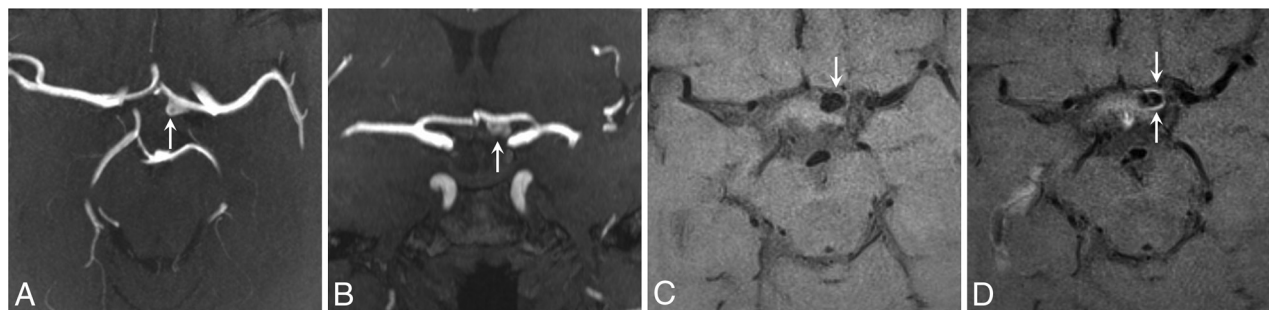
This series includes TOF-MRA scans (A and B) and precontrast (C) and postcontrast (D) T1-weighted 3D TSE sequences showing a 7 × 6 mm unruptured aneurysm in the left anterior cerebral artery (arrows). The delayed postcontrast image (D) reveals circumferential enhancement of the dome of the aneurysm, indicating wall instability, denoted by opposing white arrows.
